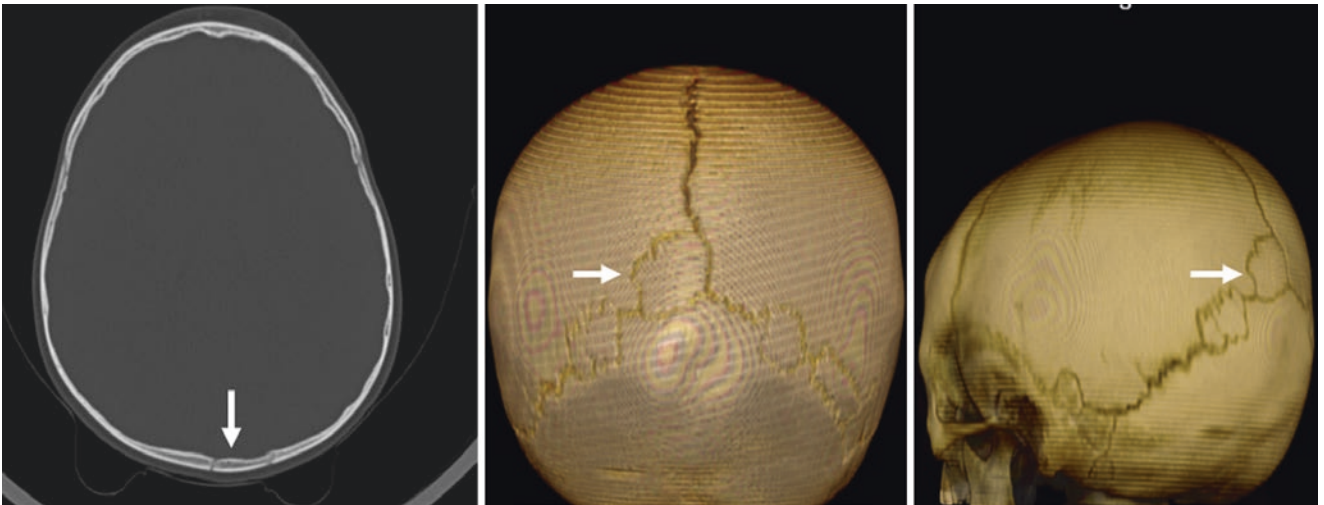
A 2.5 year old with multiple intrasutural bones, including bones within the PF and lambdoid sutures on axial (*left*, and on 3D VR CT posteroanterior (*middle*) and LPO (*right*) views
